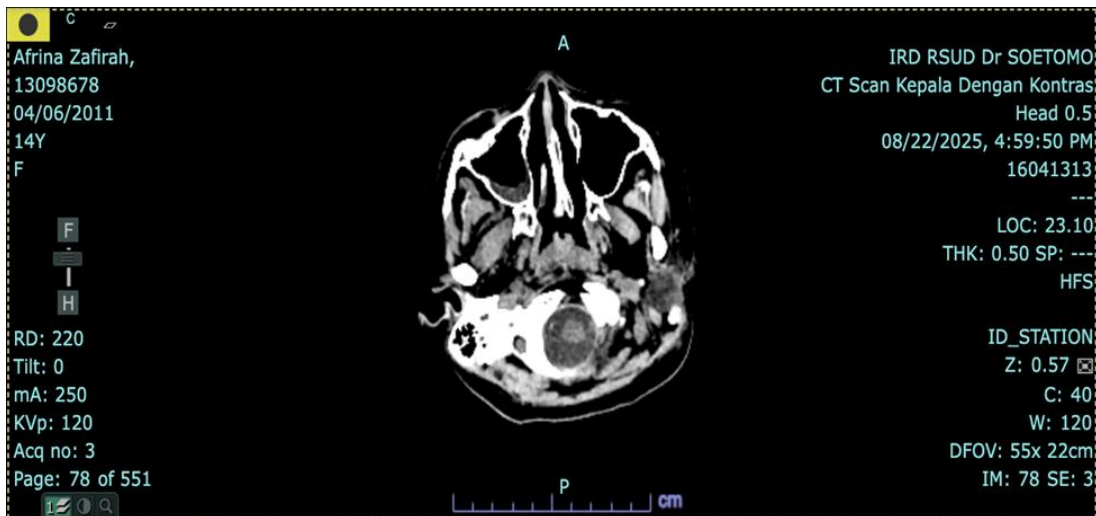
Result of a contrast head CT on 22 August 2025.
